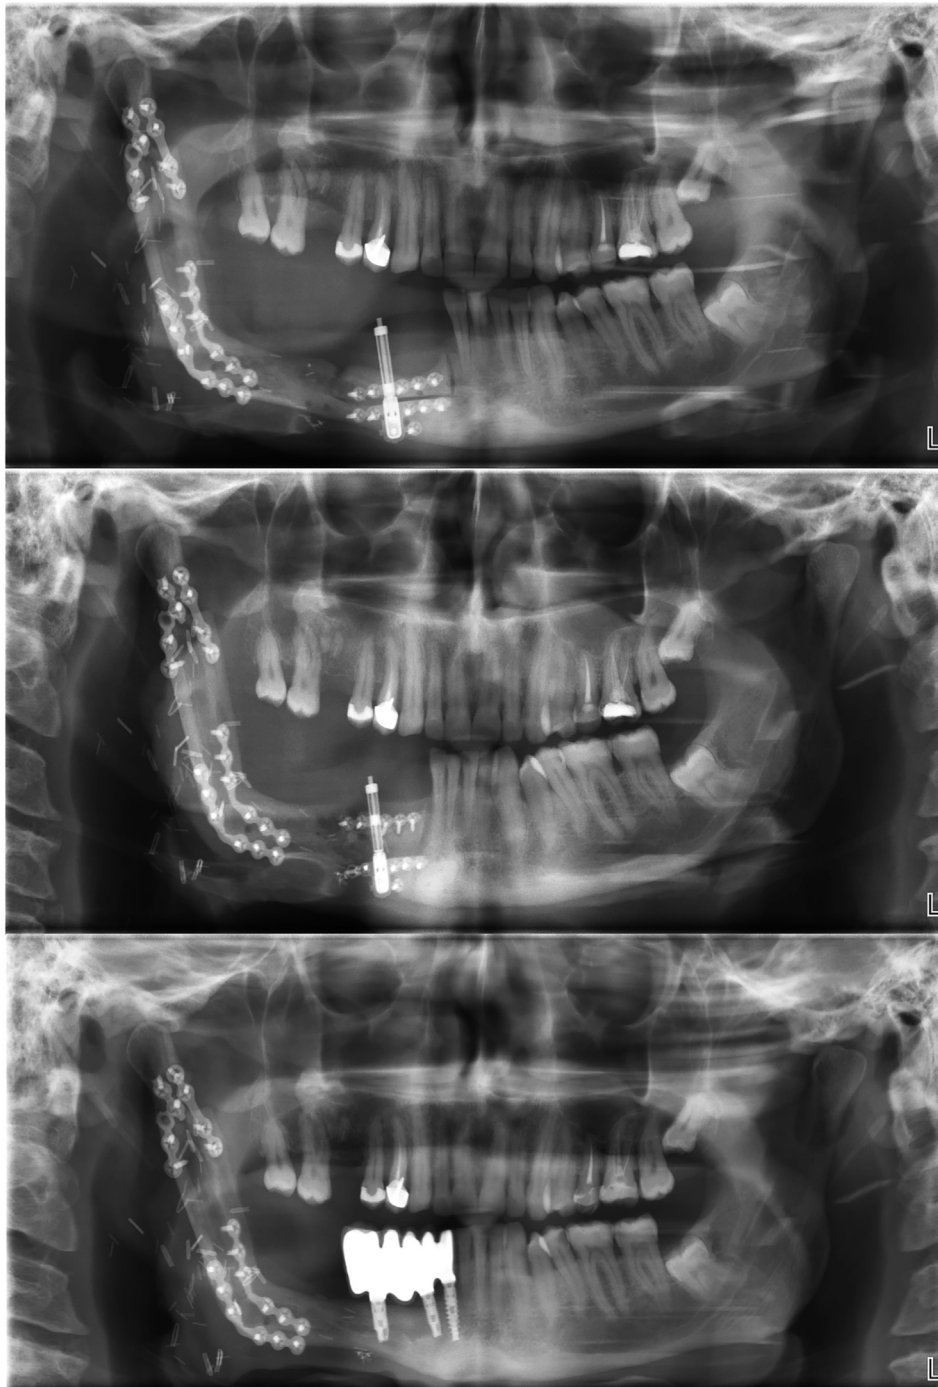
Case 4. Panoramic x-ray images. Top: at the beginning of osteodistraction; Middle: at the end of osteodistraction; Bottom: at the 7-year follow-up.
